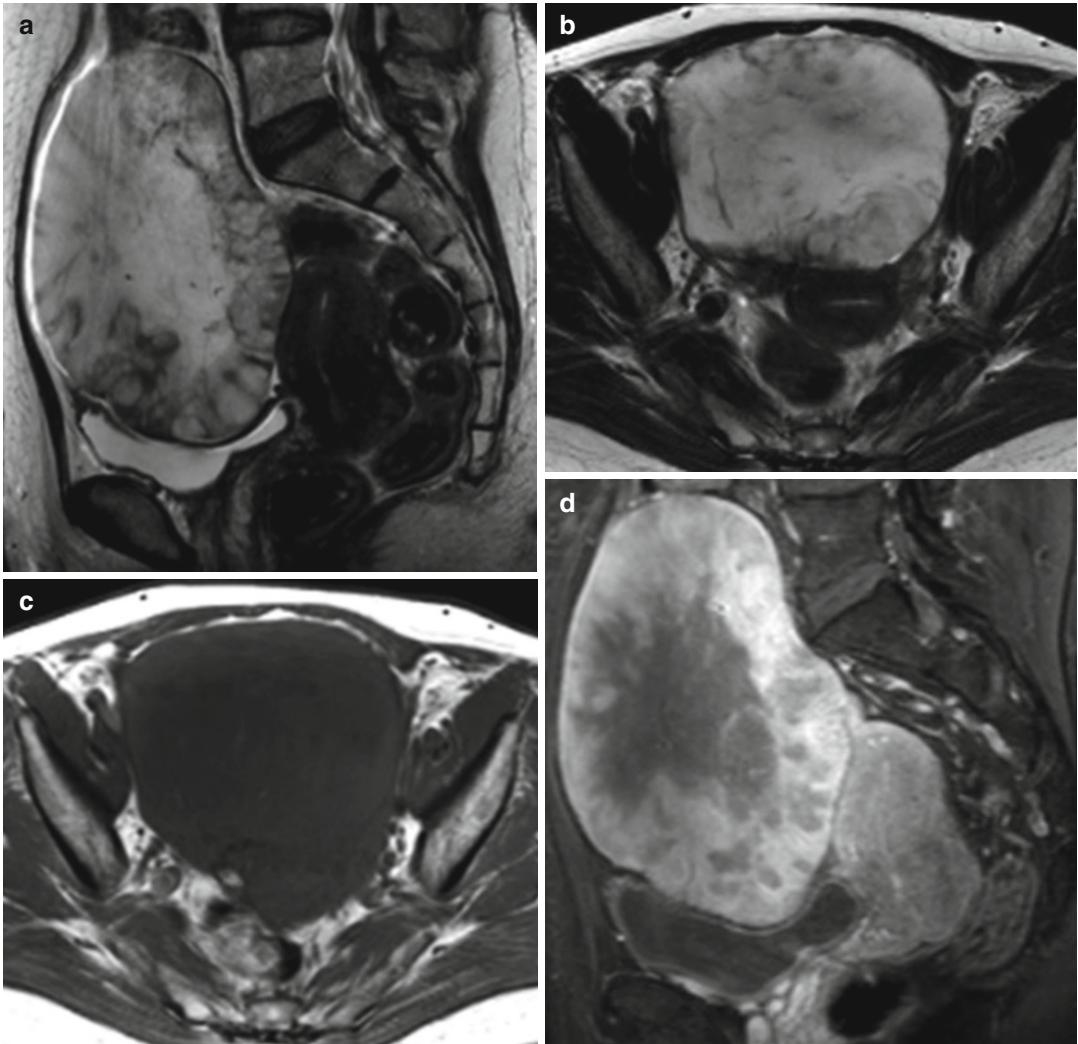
Krukenberg. A 56-year-old patient with gastric adenocarcinoma and elevated CA125. There is a large pelvic mass with heterogeneous high signal intensity on T2-weighted images (TR:4361, TE:80; a, b) and low
